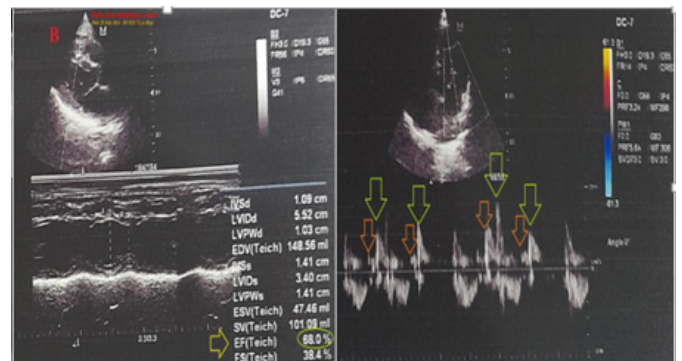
Later echocardiography.
